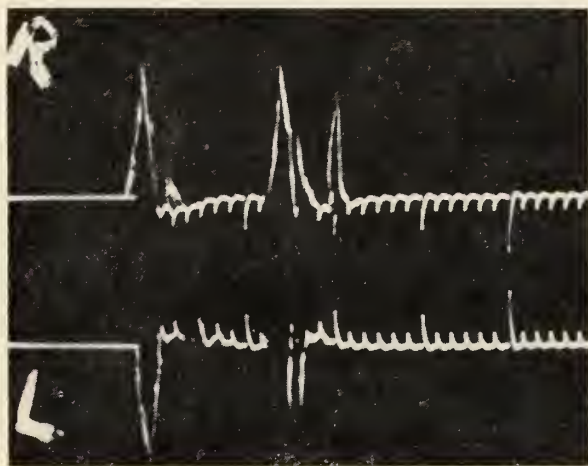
(Case 1.) Comparative A-mode sonogram of right and left eye. Difference in size is noticeable (L=18 mm, R=22 mm). Multiple echoes in corpus vitreous, especially in left eye.
